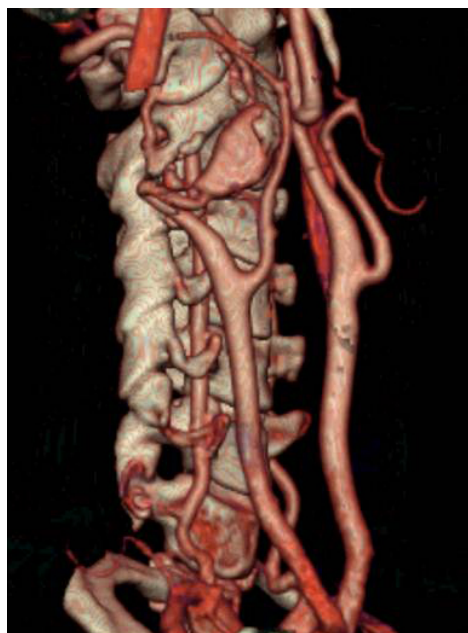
3D Angio- CT Scan: Lateral View of the right carotid axis
